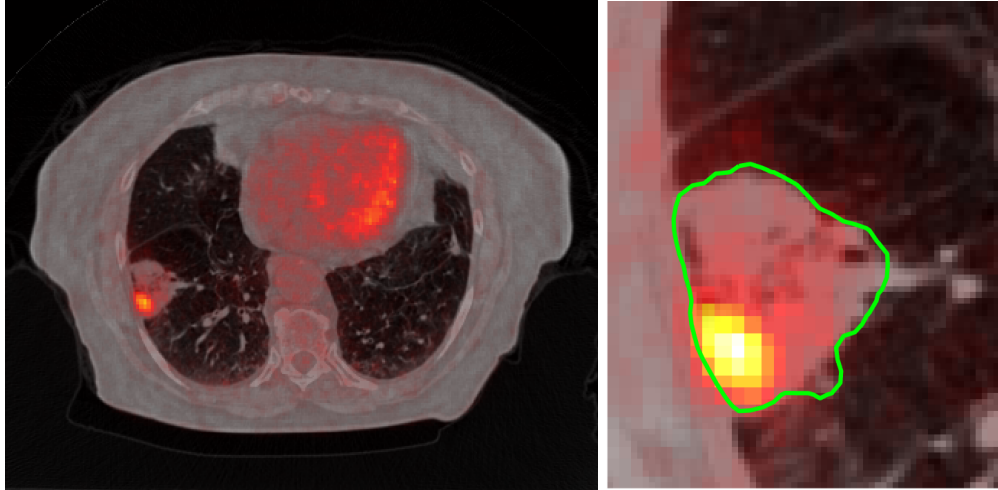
Left: axial CT slice and PET image overlay after the alignment and rescaling of the PET image. Right: closeup view of the ROI (green).
